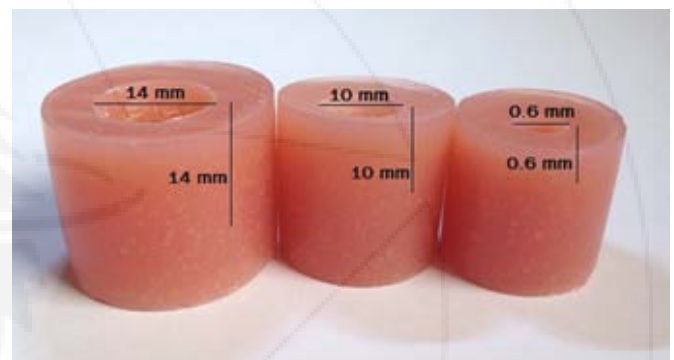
Models of methyl methacrylate of periapical lesions
